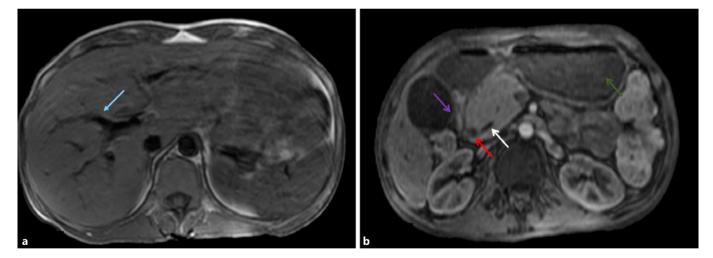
MRI showing dilation of the intrahepatic bile ducts, CBD and main pancreatic duct, findings related to the notorious architectural distortion present in the duodenal region. Blue arrow, dilated intra-hepatic duct; white arrow, main pancreatic duct; red arrow, common bile duct; green arrow, stomach; purple arrow, duodenum.
